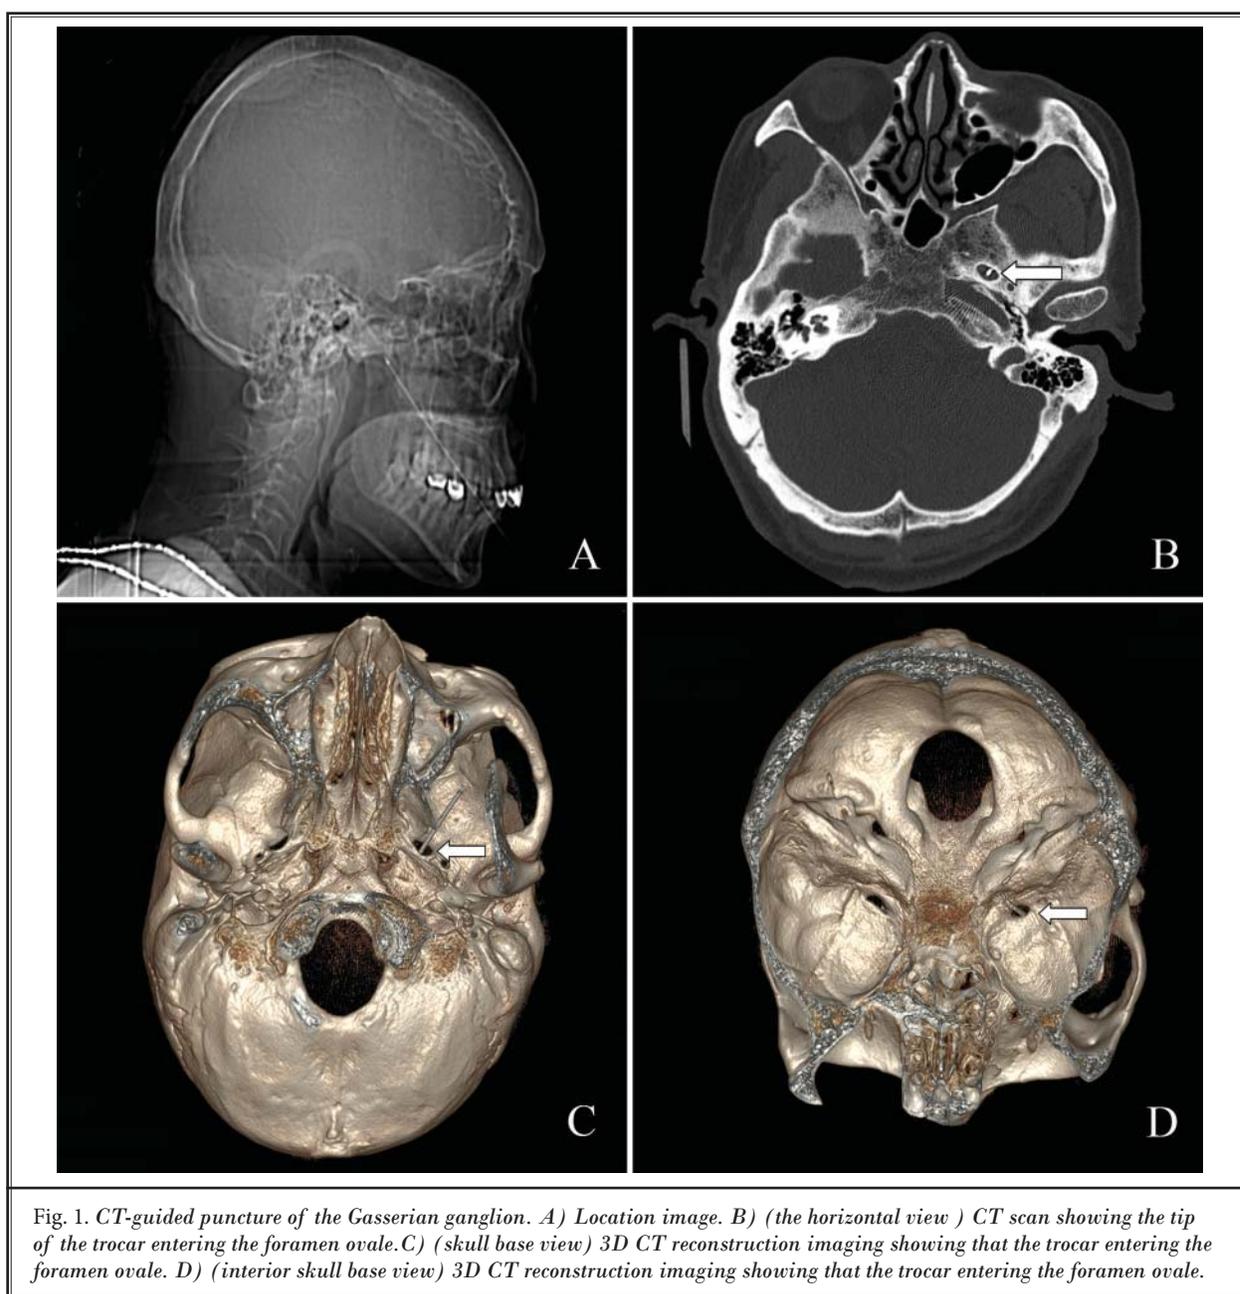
CT-guided puncture of the Gasserian ganglion. A) Location image. B) (the horizontal view) CT scan showing the tip of the trocar entering the foramen ovale. C) (skull base view) 3D CT reconstruction imaging showing that the trocar entering the foramen ovale. D) (interior skull base view) 3D CT reconstruction imaging showing that the trocar entering the foramen ovale.
